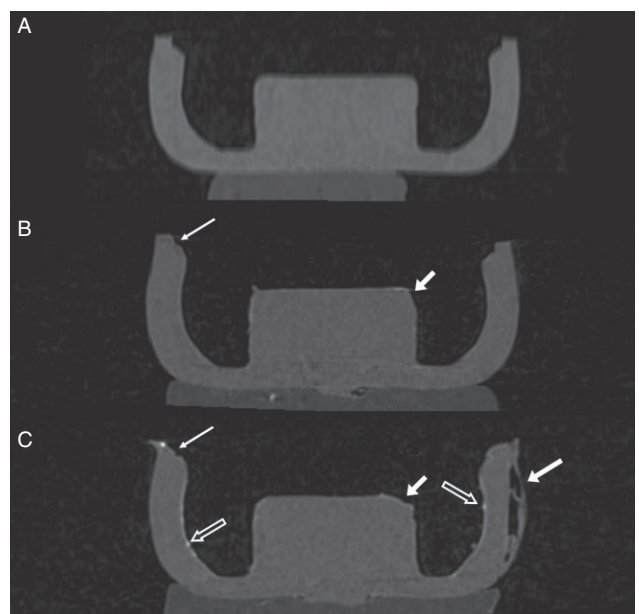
A*, Micro-computed tomography (μ CT) of the nylon insert of a new LA attachment. *B*, Nylon insert after 1 week of clinical service showing early deformation of the peripheral edge (narrow arrow) and the edge of the internal core (short wide arrow). *C*, Insert after 1 year of service showing deformation of the peripheral edge (narrow arrow), internal and external tear (wide arrows), and mineralized deposition of plaque on the internal surface (outlined arrows).
